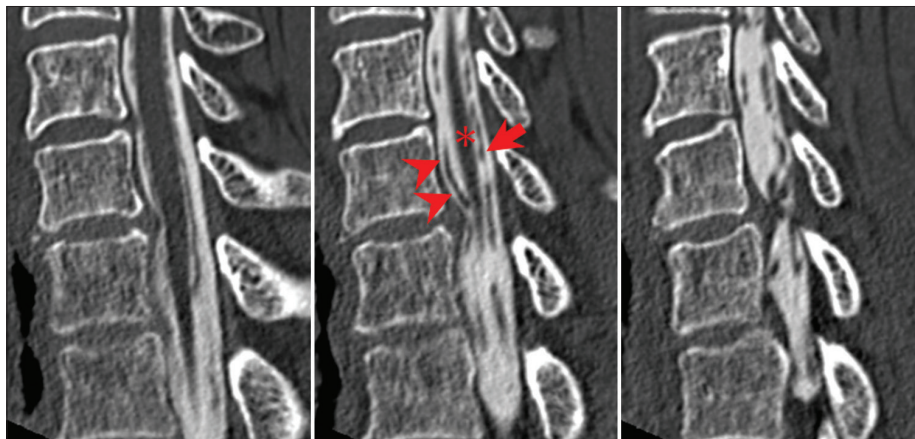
Sagittal section of computed tomography myelogram showing posterior deviation of the ventral rootlet (arrowheads: ventral rootlet, arrow: dorsal rootlet, and asterisk: spinal cord). Ventral rootlet identification was confirmed by examining serial slices of the sagittal section.
